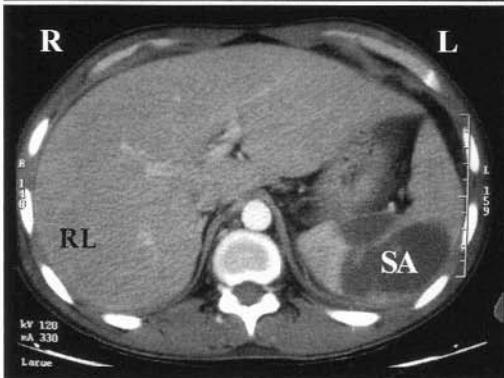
CT abdomen showing multiple hypodense areas in the spleen suggestive of abscess (SA). RL = right lobe of liver.
